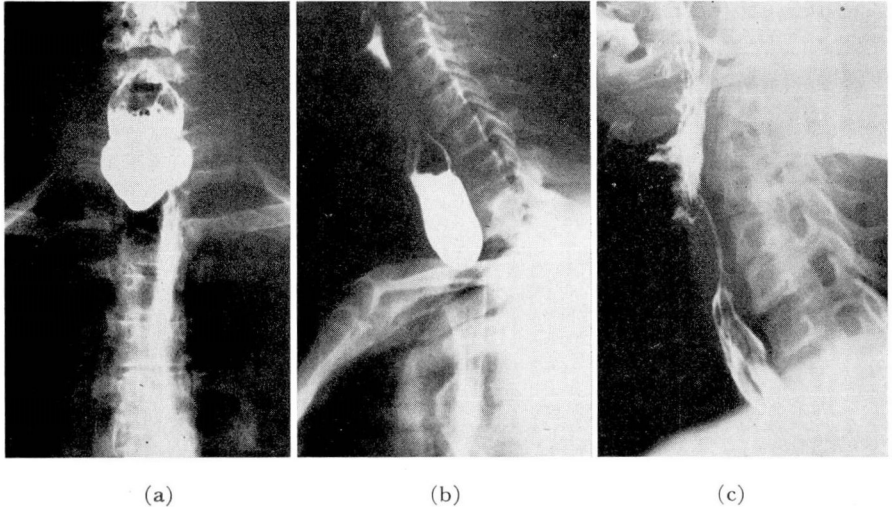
(a and b) Case 1. Preoperative x-rays revealing large pharyngo-esophageal diverticulum. (c) Postoperative x-ray. No evidence of recurrence.
